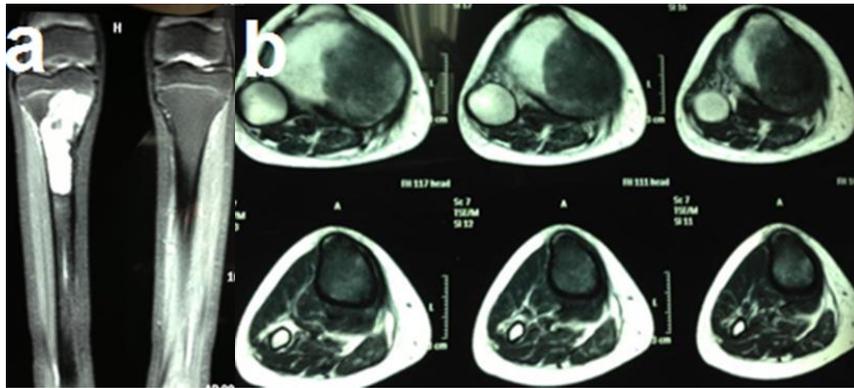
MRI cuts (a) coronal cut (b) axial cut showing medullary involvement and minimal soft tissue extension.
